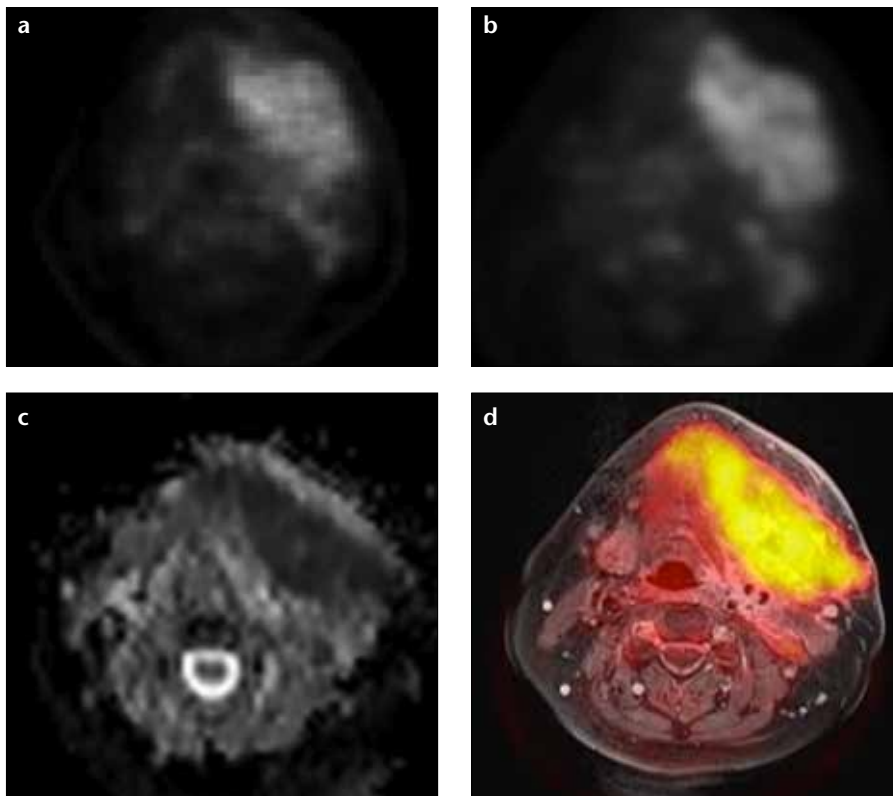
a–d. Images of a large cancer of unknown primary of the head and neck region derived from PET/MRI. This example demonstrates visually comparable quality of PET/CT (a) and PET/MRI (b) derived PET images. Simultaneous PET/MRI offers the possibility of morphological, functional and metabolic imaging studies in a single examination (c, d). Diffusion-weighted imaging (ADC map; $b=[0, 500, 1000]$) of the lesion is shown in (c). Fusion of T1-weighted contrast-enhanced image with fat saturation and attenuation-corrected FDG-PET is shown in (d).
